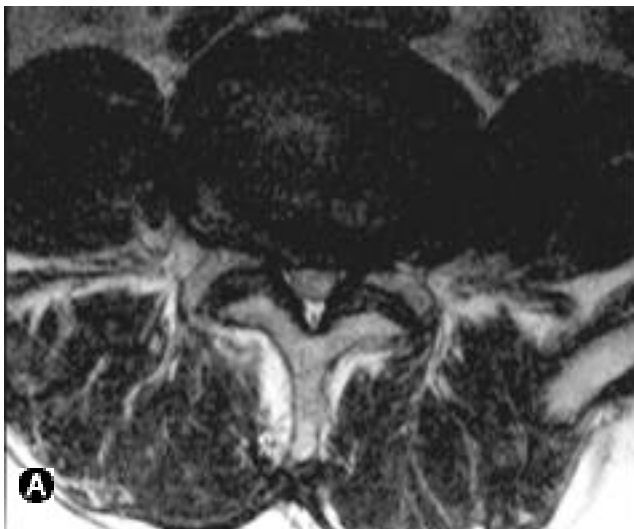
Preoperative MRI image (A) and postoperative CT image (B) of laminoplasty patient.
